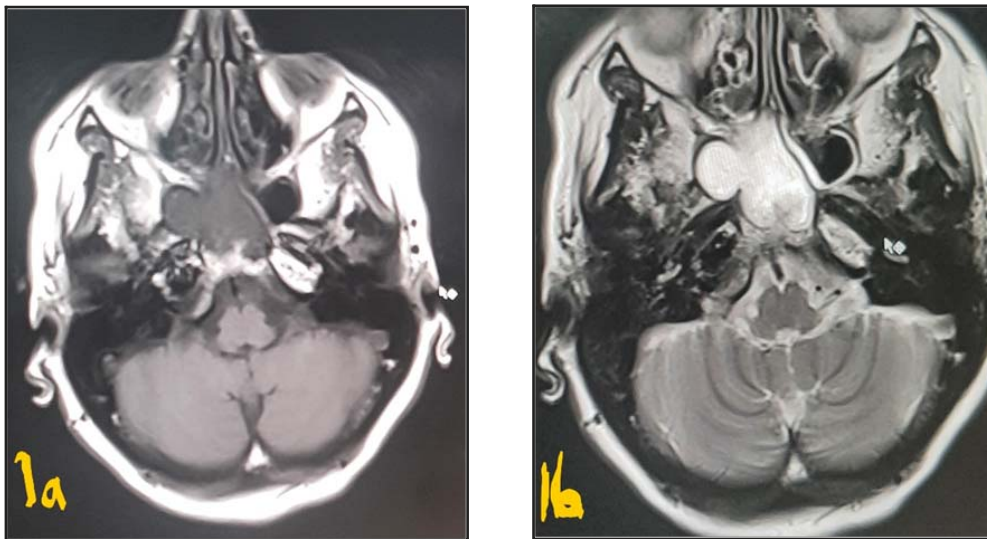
Axial plane MRI through the sphenoid sinus (a. T1 and b. T2) both show cystic lobulated lesion occupied RT sphenoid sinus, features of sphenoid sinus mucocele.
